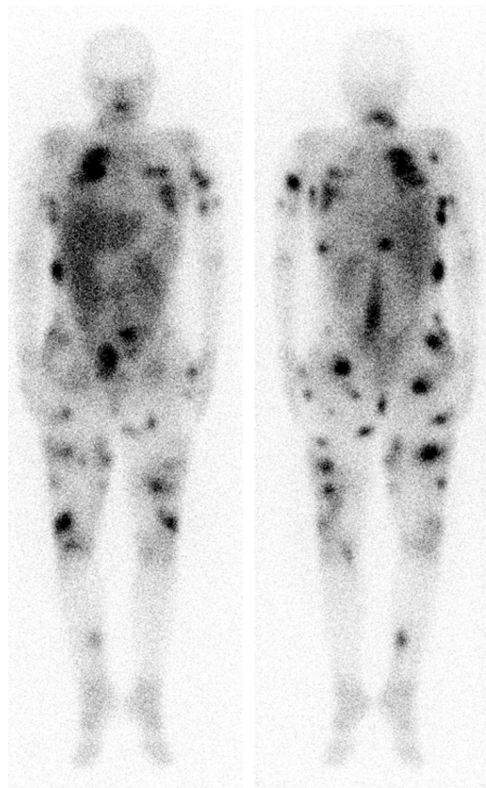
Whole-body gallium-67 scintigraphy. A 25-year-old woman presented with neutropenic fever after chemotherapy for the relapse of acute biphenotypic leukemia. She was treated empirically, but still had fever up to 39.5°C. Physical examination was unremarkable except her paleness and elevated body temperature. Laboratory investigation revealed pancytopenia (hemoglobin, 72 g/L [normal range, 120–160]; white blood cell count, 40/mL [normal range, 399–10,390]; platelet count, 14,000/mL [normal range, 130,000–400,000]). Blood culture result was positive for *Pseudomonas aeruginosa*. Chest x-ray showed marked infiltration within bilateral lower lung fields. Urinalysis was negative for any infection. Because the patient had no localizing signs or symptoms, she underwent Gallium-67 scintigraphy for the identification of infectious foci.^{1–5} Gallium-67 scan demonstrated a unique pattern of numerous foci with intense and varying-sized radioactivity spreading throughout the body.
